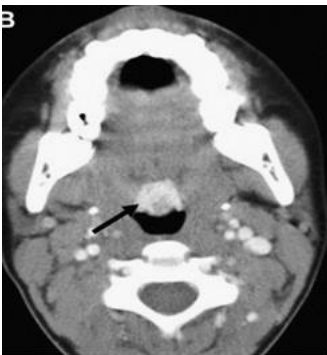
Lingual thyroid: A 20-year-old woman's axial CT scan at the base of her tongue and foramen cecum shows a sizable hyperdense mass (black arrow). A lingual thyroid is indicated by uptake at the foramen cecum level on a radioiodine scan. The rest of the neck showed no thyroid tissue.
